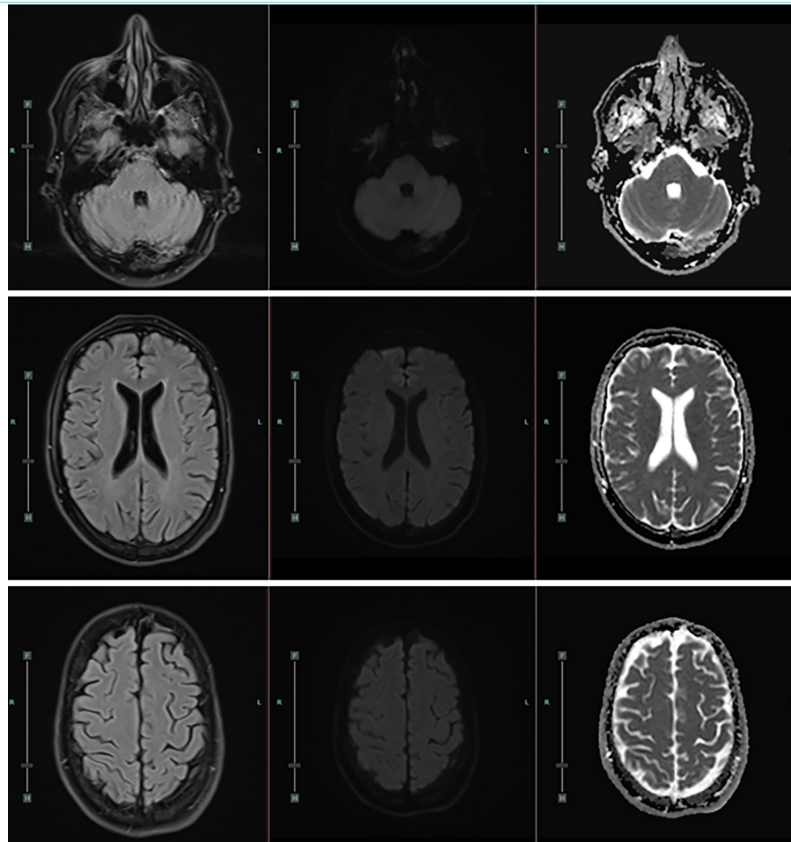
Demonstrating complete resolution of previously noted vasogenic edema in the brainstem, cerebellum, and temporo-parieto-occipital regions, indicating radiological improvement in follow-up MRI.
